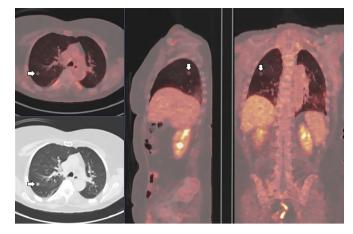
Computed tomographic and positron emission tomographic images show a well-defined lung lesion in the right upper lobe (arrow) with a maximum diameter of 9 mm. There was no fluorodeoxyglucose uptake.
